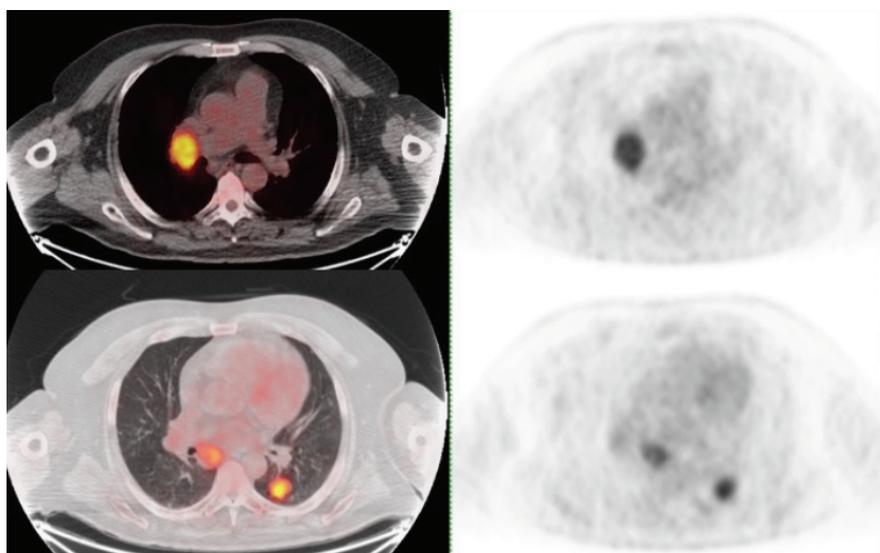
A 56-year-old man with classic type papillary thyroid cancer, previously received 200 mCi I-131 treatment. He was referred for clinical progression. Lesions with high ¹⁸F-FDG uptake were found in the mediastinum and lung parenchyma (Tg: 1.853 ng/mL, anti-Tg: 0.9 ng/mL) I-131: Iodine-131, ¹⁸F-FDG: ¹⁸Fluoride-fluorodeoxyglucose, Tg: Thyroglobulin
